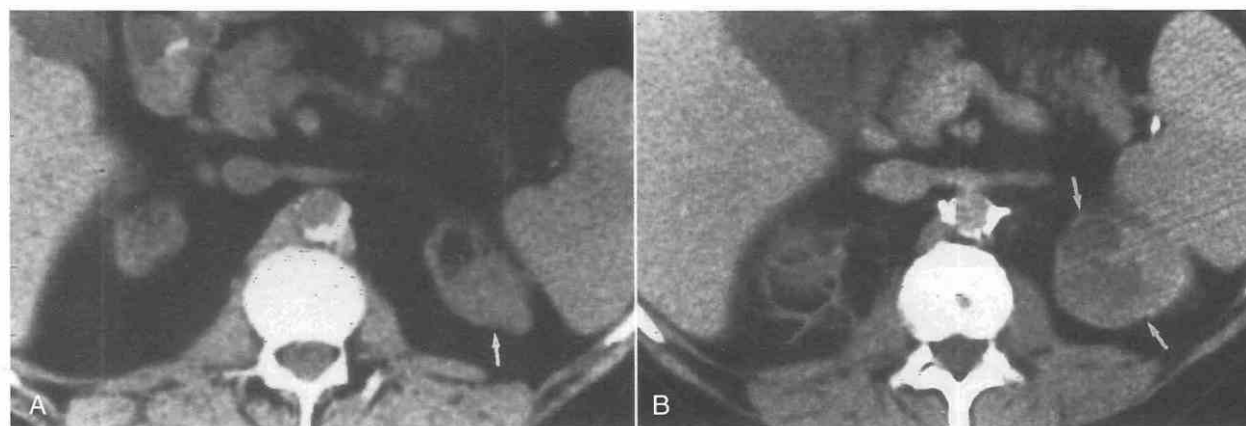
Growth of renal cell carcinoma in a patient with acquired renal cystic disease who was undergoing hemodialysis. *A*, The first CT scan shows a small mass (*arrow*) in the upper pole of the left kidney. *B*, A CT scan performed 18 months later during an episode of gross hematuria reveals that the left renal mass (*arrows*) has enlarged and become heterogeneous, suggesting renal cell carcinoma. On pathologic examination, the lesion had invaded the renal capsule. Linear strands related to the right kidney resulted from perinephric hemorrhage. (From Levine E, Grantham JJ, MacDougall ML: Spontaneous subcapsular and perinephric hemorrhage in end-stage kidney disease: Clinical and CT findings. *AJR Am J Roentgenol* 148:755–758, 1987.)
